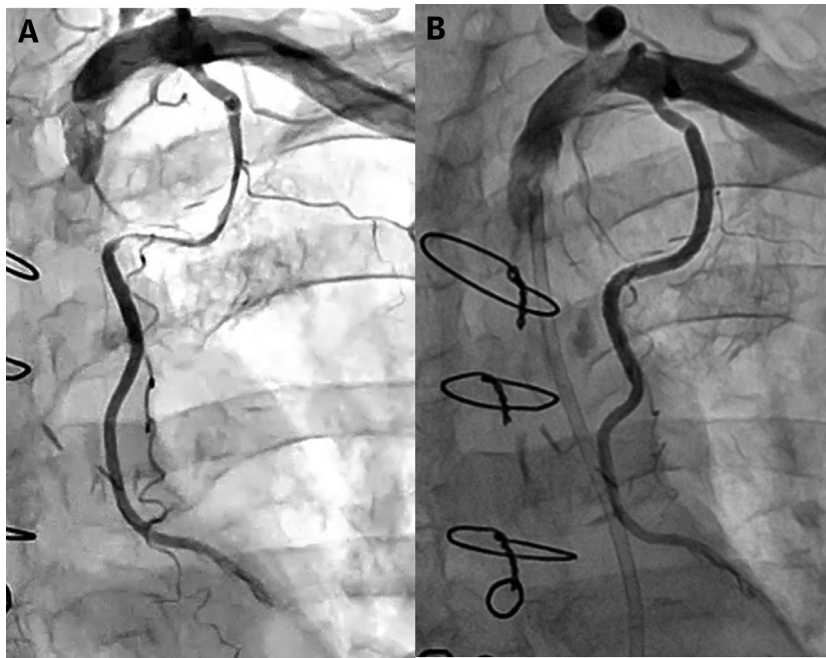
Angiography of the IMA Graft(A) Internal mammary artery (IMA) angiography from 1 year ago. (B) IMA graft angiography at the onset with Thrombolysis In Myocardial Infarction flow grade 2.FIGURE 3 Intravascular Ultrasound FindingsAngiography and intravascular ultrasound findings. Asterisks show intramural hematoma.
